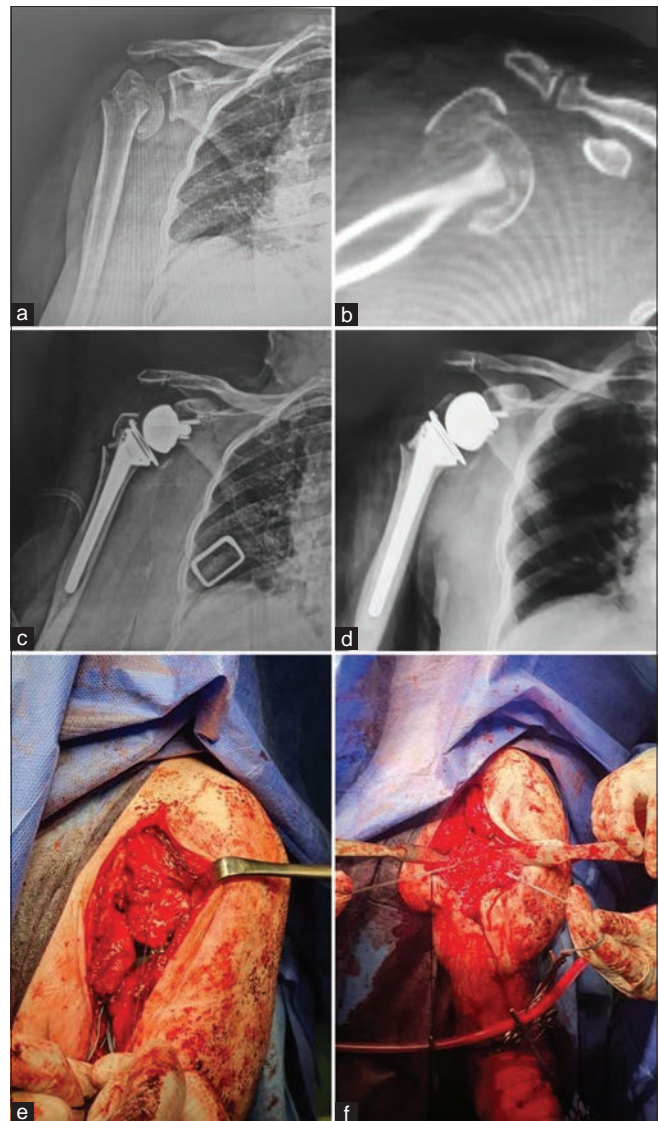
(a) Preoperative plain X-rays of patient with acute proximal humerus fracture, (b) preoperative Computed tomography scan, (c) postoperative X-rays, (d) last follow-up plain X-rays. (e) Sutures passed through holes medial and lateral to bicipital groove, (f) Reduction of both greater and lesser tuberosities
